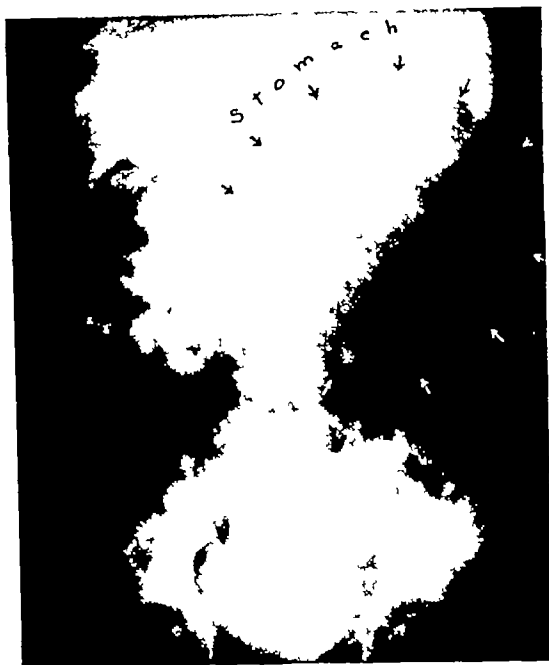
Case 5 Roentgenogram of duplication of stomach showing a large mass outlined by arrows beneath the stomach. The stomach is filled with barium and is indented along its greater curvature by the mass.
